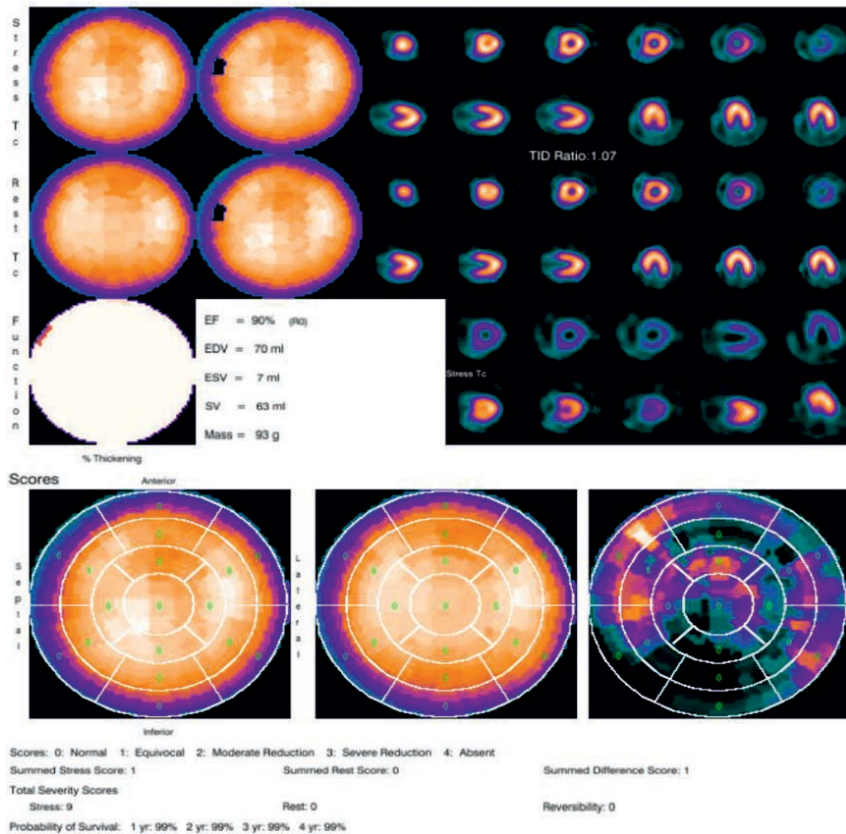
^{99m}Tc -Sestamibi myocardial perfusion scintigraphy showing all myocardial segments show normal perfusion showing normal perfusion on cardiac stress and rest MPI.
